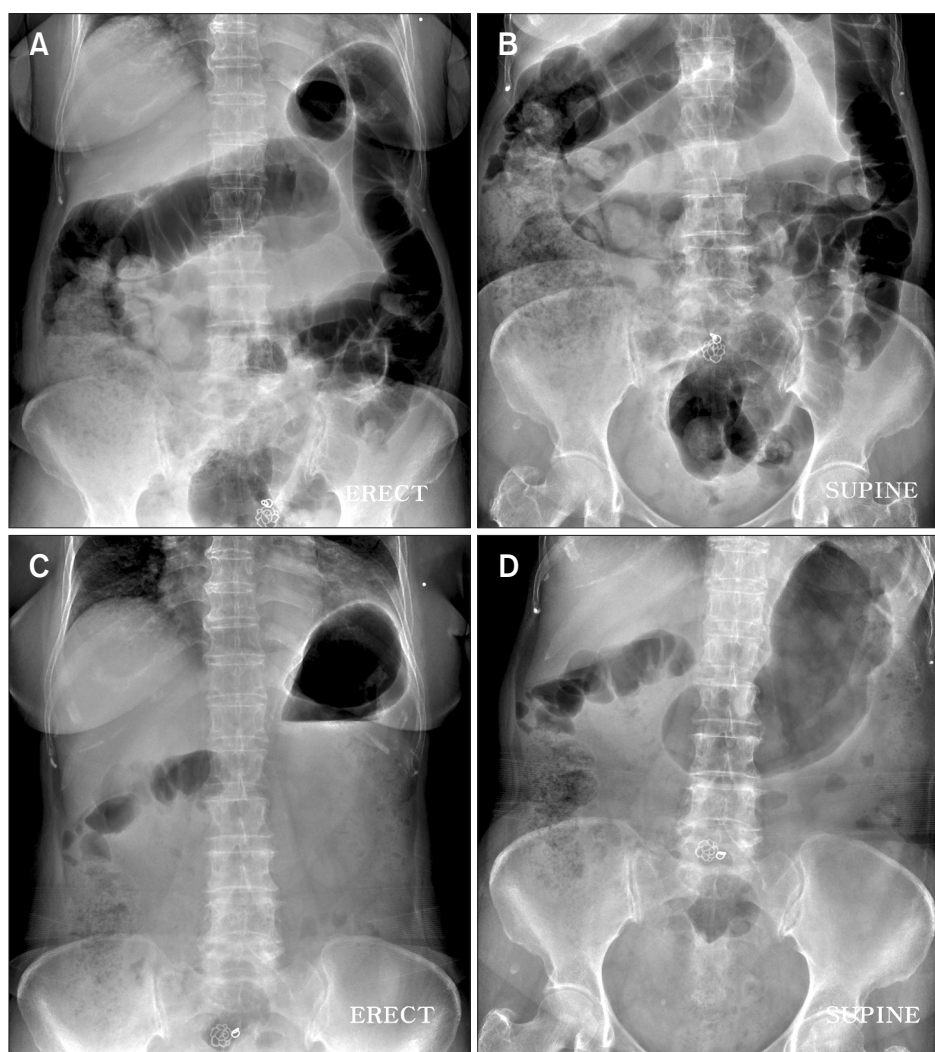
Radiographic findings. (A, B) Abdominal X-ray on admission shows diffuse colonic dilatation. (C, D) Colonic dilatation disappears after 10 days of conservative management.
